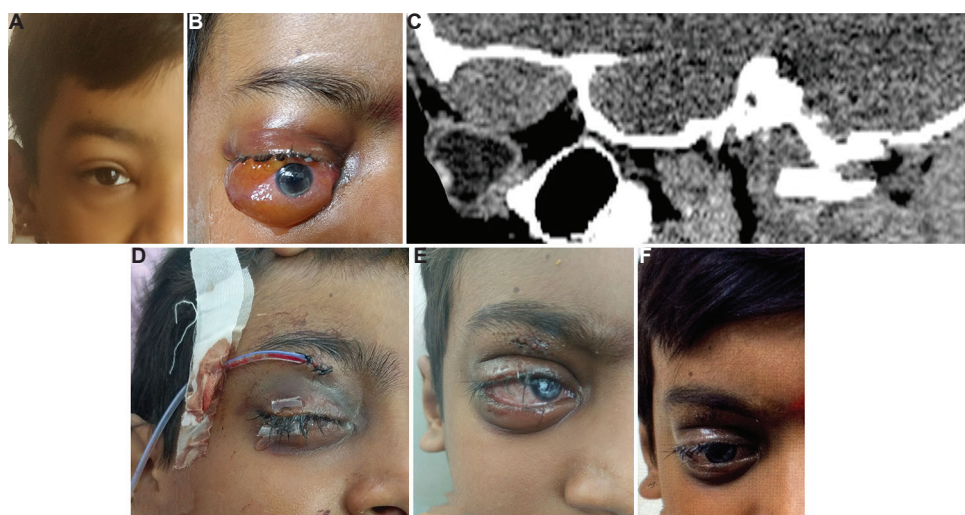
(A) The patient on presentation after trivial trauma to the forehead, with swelling seen on the right eye. (B) Increased intraorbital swelling causing severe proptosis with exposure keratopathy causing decrease in vision. (C) Computed tomography orbit showing hyperdense biconvex lesion in the superior orbit, suggestive of subperiosteal haematoma with the orbital roof intact. (D) After wide-bore needle aspiration, drain was put as there was continuous bleed. (E) Postoperative one-week proptosis completely reduced with resolving corneal infiltrates. (F) At one-month follow up, the patient had an inferior corneal opacity with vision of 6/12.
